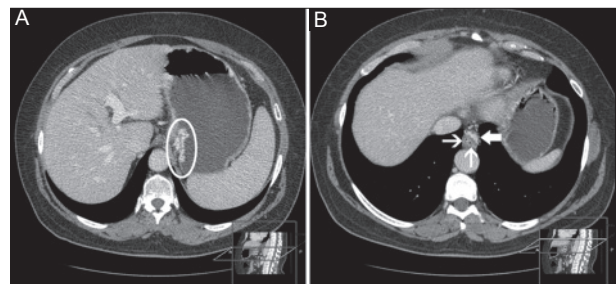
False positive computed tomography (CT) scans for gastric and esophageal varices. (A) Large varices are demonstrated within the stomach, although the endoscopy was negative. (B) False positive CT for esophageal varices. Subserosal varices are clearly viewed (thick arrow). The small hyperdense dots (thin arrows) were thought to be submucosal varices but the endoscopy did not confirm the diagnosis
